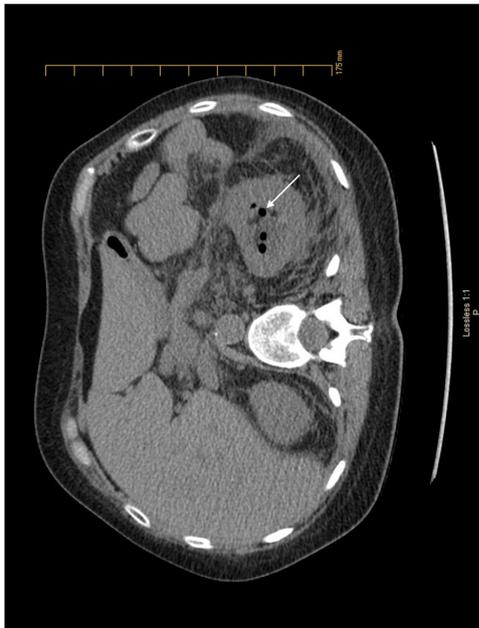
CT scan of the abdomen and pelvis showing air in the proximal left ureter (arrow).
